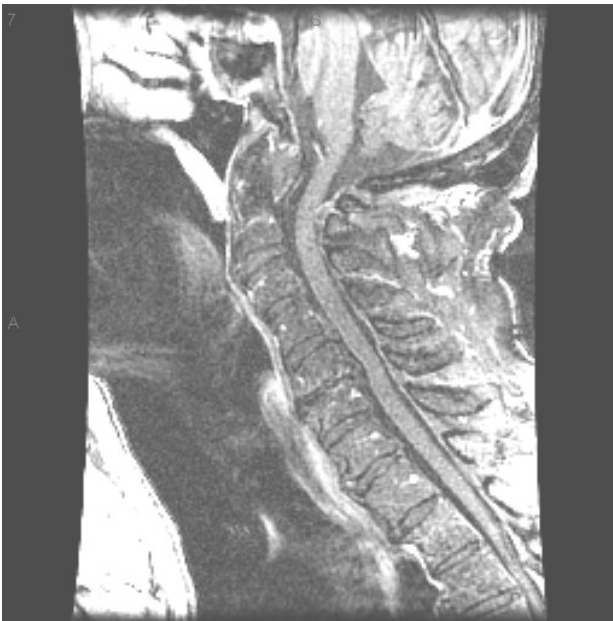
MR image of the sagittal c-spine. (Permission from Dr. Deborah J. Rubens)
